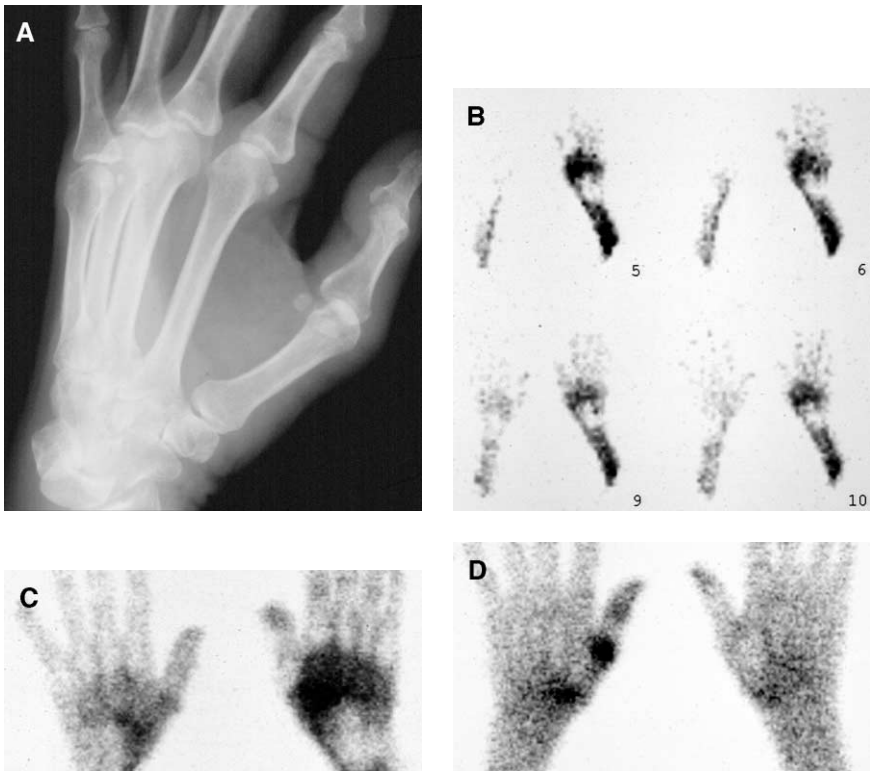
Patient with a history of puncture wound at the base of the thumb. Plain radiograph (A) of the hand is normal. Three phase bone scan (B–D) demonstrates increased flow of radiotracer to the soft tissues and increased uptake in the bone consistent with osteomyelitis involving the base of the first metacarpal bone.
